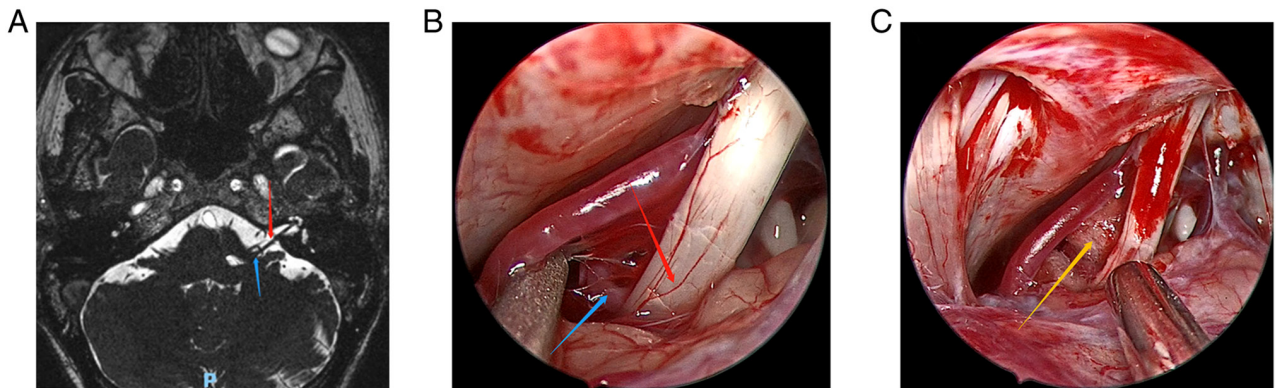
Patient 4. (A) Preoperative head magnetic resonance imaging of the patient. (B) The the posterior inferior cerebellar artery and compressed cranial nerves were clearly visible under the endoscopic view. (C) The Teflon pad was placed between the root exit zone of cranial nerve 7 and the posterior inferior cerebellar artery under the endoscopic view. Red arrows indicate the compressed cranial nerve vessels, blue arrows indicate the posterior inferior cerebellar artery and the yellow arrow indicates the Teflon pad.
